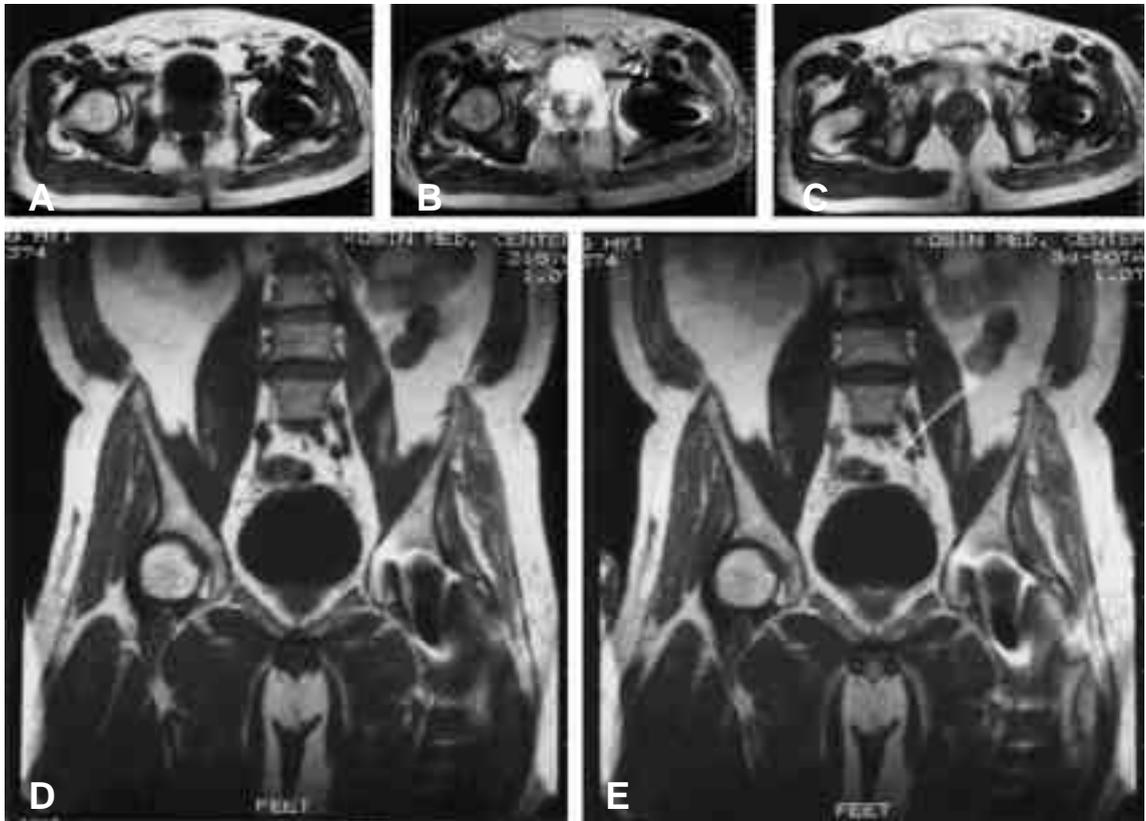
63 year-old-male. Renal cell cancer. Initial MRI
